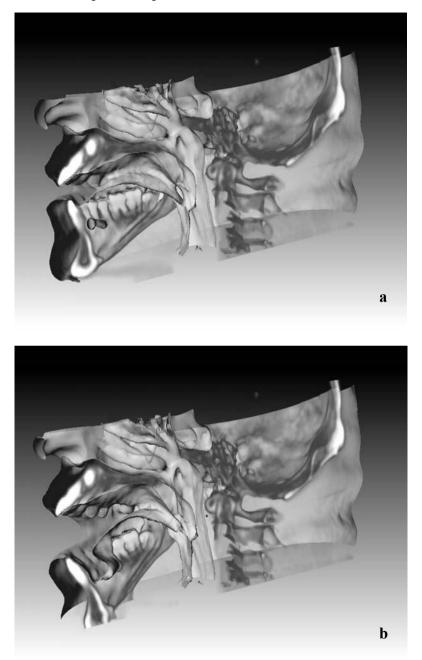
4D-visualization of orofacial soft tissue based on 256 row 4D-CT, red-cyan-stereo, a: start, b: end of movement
